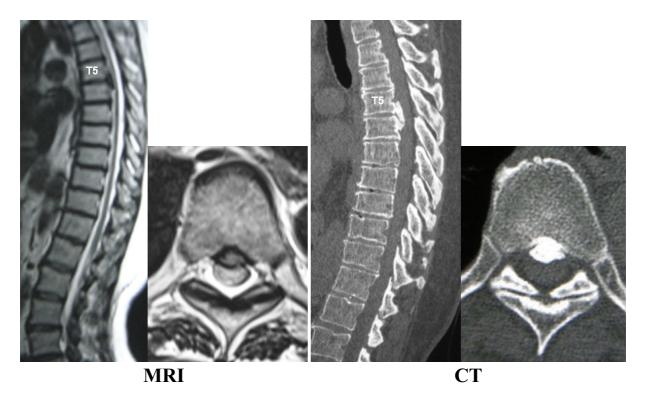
Preoperative MRI and CT images of beak-type OPLL at T5-6.
